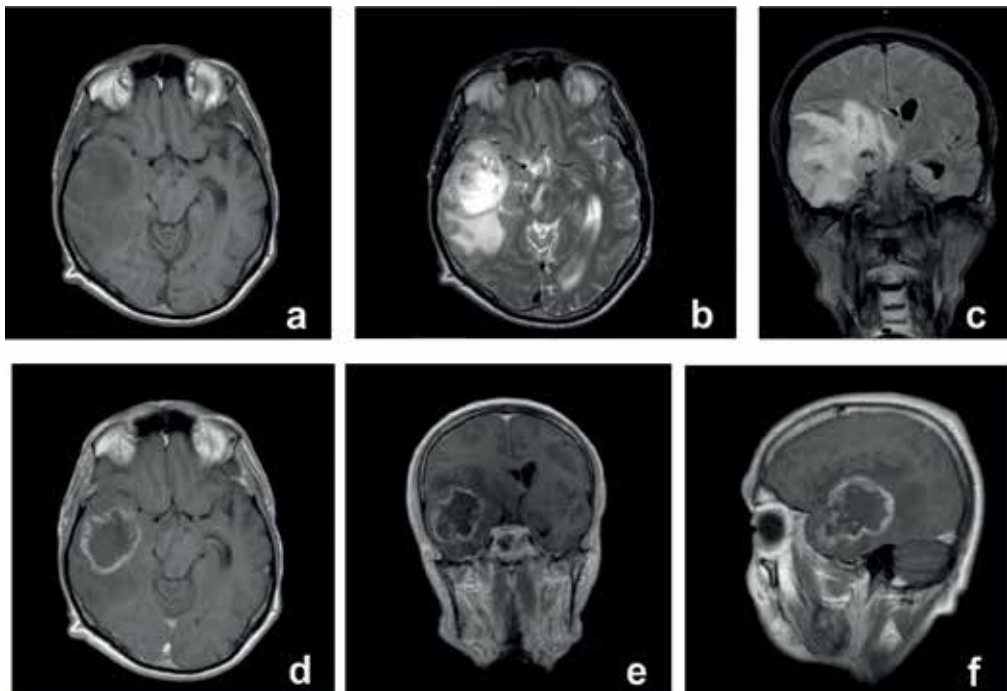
Right temporal glioblastoma – MRI features. (a) Axial T1-weighted image; (b) axial T2-weighted image; (c) coronal FLAIR sequence; (d) axial T1-weighted image with contrast; (e) coronal T1-weighted image with contrast; (f) sagittal T1-weighted image with contrast.
